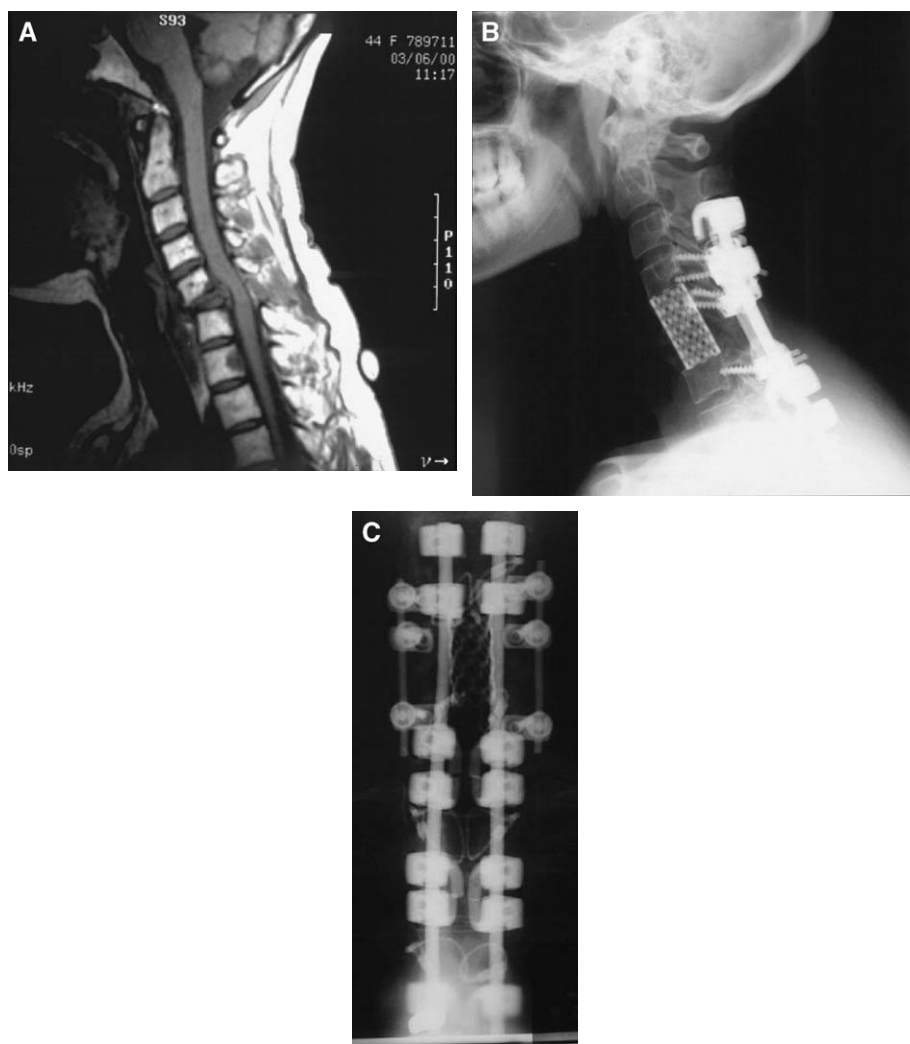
Sagittal cervical spine MRI of a 44-year-old woman with known breast adenocarcinoma with multiple metastatic lesions and a C6 pathologic compression fracture. Anteroposterior (A) and lateral (B) postoperative radiographs showing C6 to C7 corpectomies with ventral reconstruction and fusion with a titanium cage and autologous bone graft and C4 to T5 dorsal fixation and fusion with C4 to C7 lateral mass screws and C4 to T5 laminar hook and rod construct.
